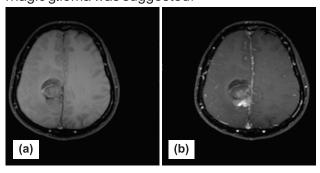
MRI findings: A) T1WI with extra-axial heterogenous, predominantly hypointense lesion arising from interhemispheric falx on right side compressing adjacent frontal lobe. B) T1 post contrast study showing heterogenously enhancing lesion towards centre with peripheral non enhancing areas.
